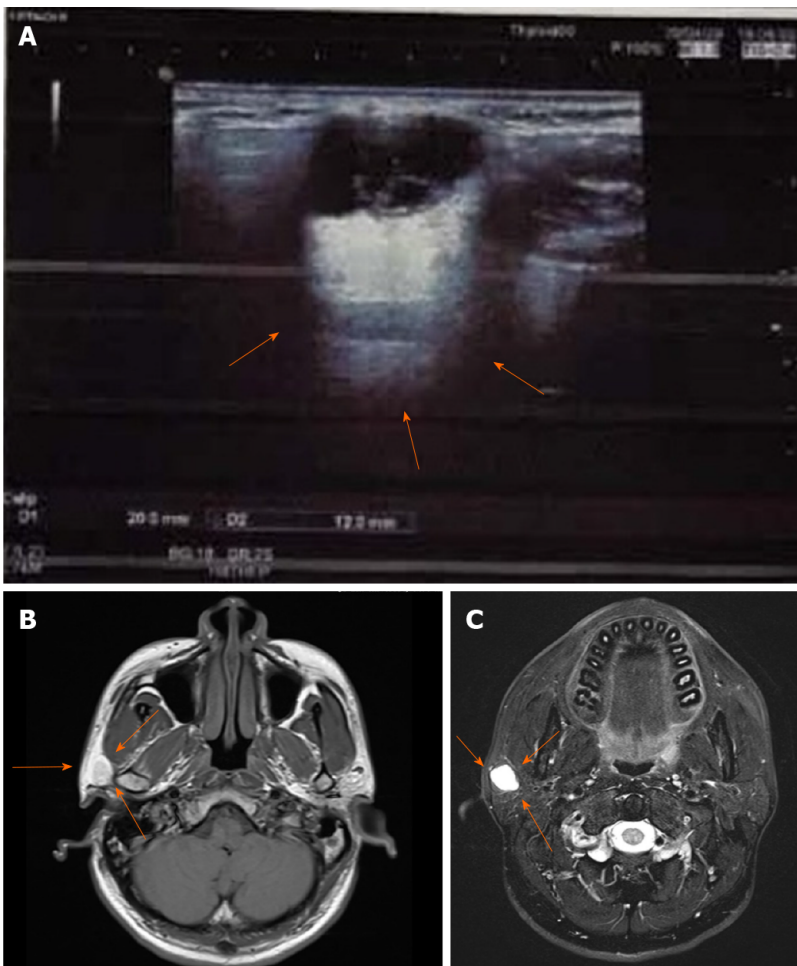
Radiological results for the lesion. A: Ultrasonic examination showing a clear boundary with strong echoes of strips and dots (arrows); B: Magnetic resonance imaging results for the lesion showing iso-low signals for T1; C: High signals for the T2 fat compression.
